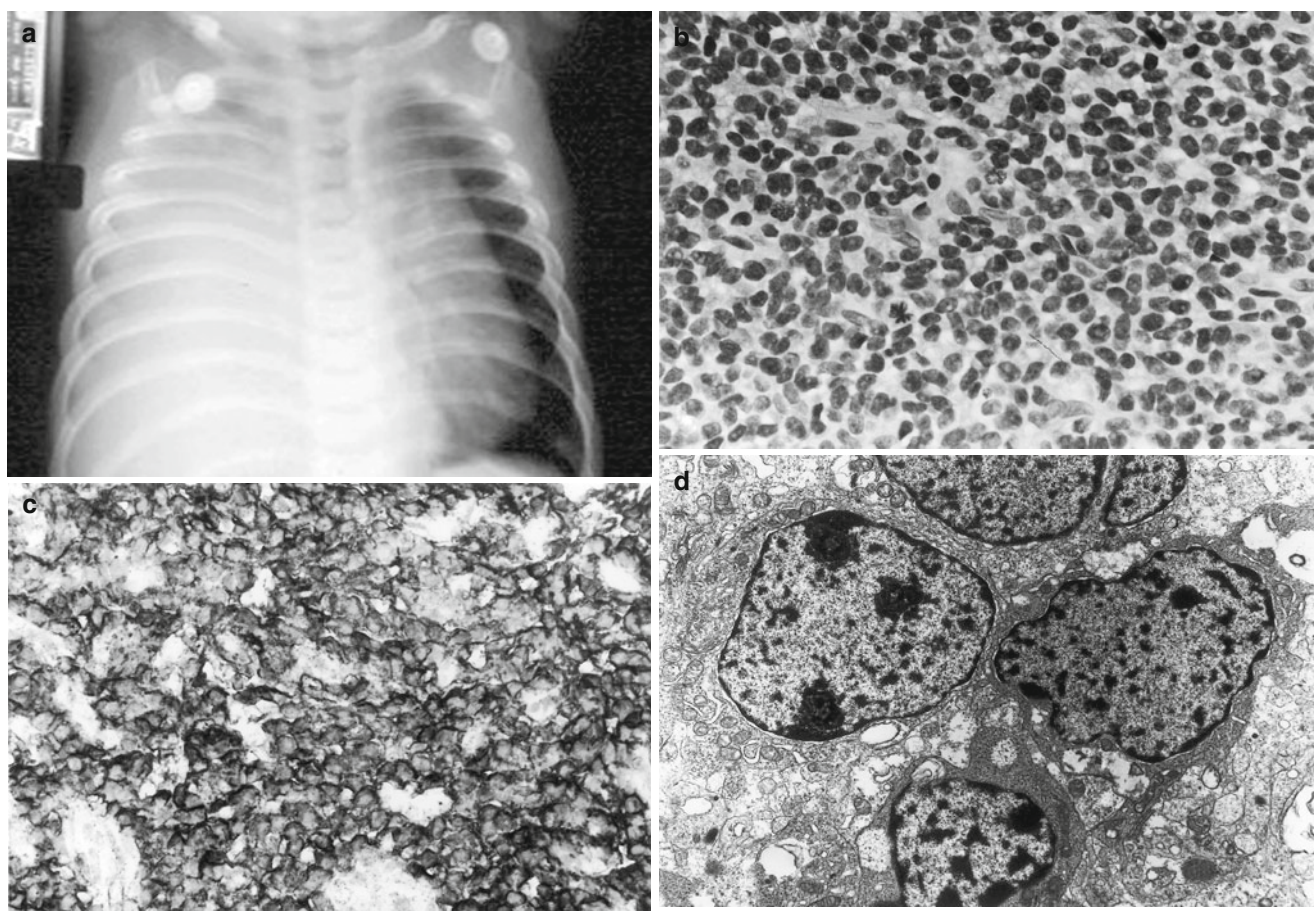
Primitive neuroectodermal tumor of thoracopulmonary origin. Six-month-old male with a chest wall mass. (a) Chest radiograph reveals consolidation of the right thorax by an infiltrative mass. (b) The biopsy shows a small cell malignant tumor forming nests of cells, which have round or oval nuclei, coarse or clumped chromatin, small nucleoli, and indistinct or scant cytoplasm. Several mitoses are present. (c) Tumor cells are diffusely immunoreactive with the Ewing's antibody
